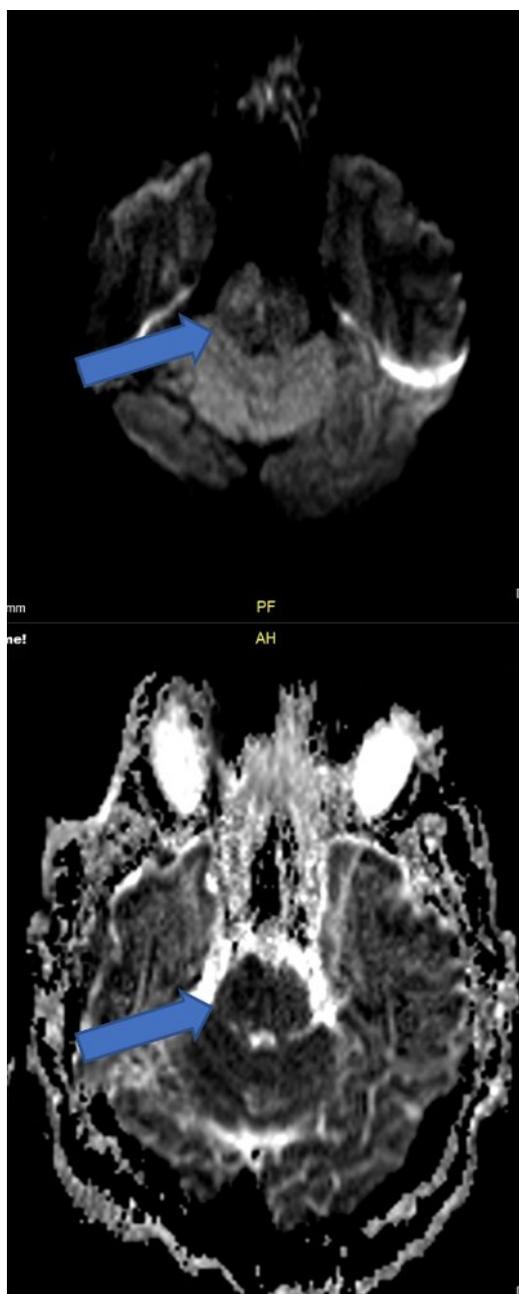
Diffusion restriction in the right pons ventral and midline in Diffusion MRI imaging (blue arrow)
